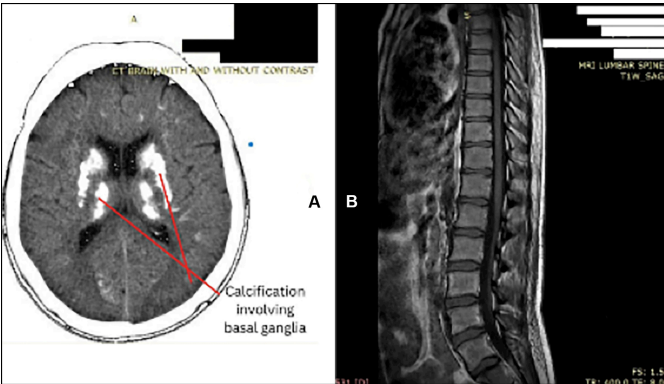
(A) CT brain showing calcifications in the bilateral basal ganglia; (B) MR spine showing normal radiological findings.
